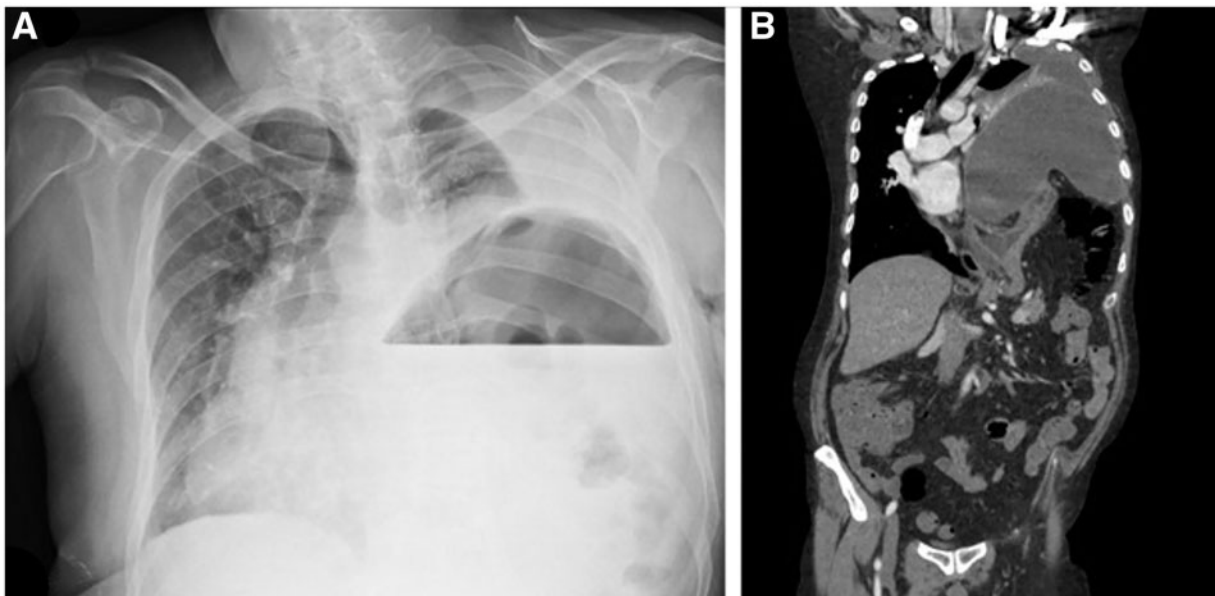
Preoperative images. X-rays showed a possible diagnosis of intrathoracic stomach in a 53-year-old man with dystonia, dysphagia and dyspnoea (Fig. 1A). Computed tomography scan demonstrated a large relaxation of the left diaphragm with the lung reduced to a small fist (Fig. 1B). A left thoracotomy was performed. A patch was used to reinforce the diaphragm. The patient is well at 2-year follow-up.
